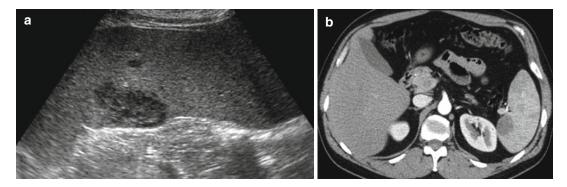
A 44-year-old male underwent an ultrasound for elevation of hepatic enzymes, which demonstrated a normal-appearing liver and increasing splenomegaly of up to 17 cm over two consecutive years. Subsequently, a focal hypoechoic mass within the spleen was incidentally depicted (a). On multiphasic contrast-enhanced CT, the mass was homogeneously hypodense during arterial and portal phases (b and c, respectively). MRI was also performed for further characterization. The mass was hyperintense on T2-weighted sequence (d) and hypovascular during immediate (e) and 1-min post-contrast (f) phases of the dynamic series, with demonstration of delayed enhancement (g). Due to its nonspecific appearance, FDG PET-CT was also carried out, demonstrating hypermetabolism of the mass (h), with absence of other FDG avid lesions (i). Splenectomy was performed, which showed presence of a primary splenic high grade non-Hodgkin lymphoma
